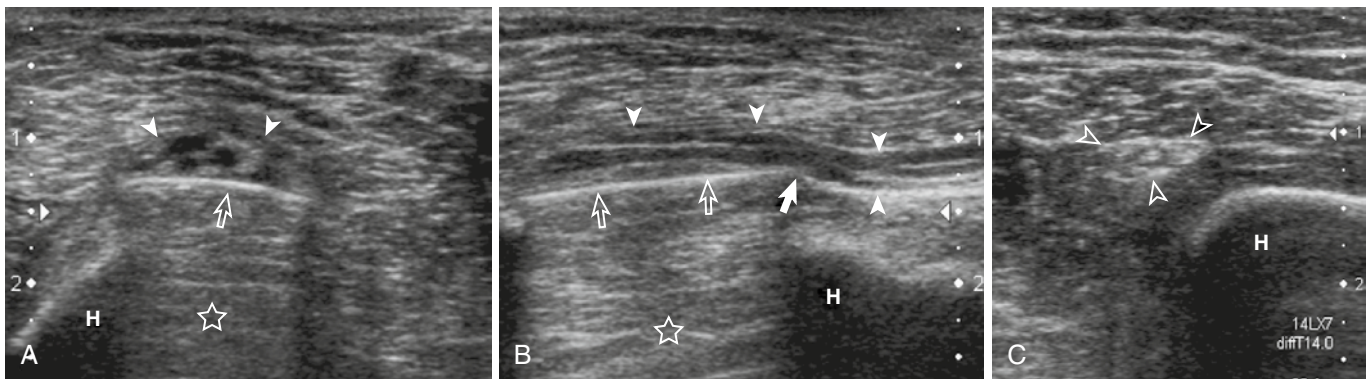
RADIAL NERVE TRACTION TRAUMA. A traumatic humeral shaft fracture was treated with internal fixation and was associated with radial nerve palsy. A and B, Short- and long-axis, 5- to 14-MHz ultrasound images show an enlarged radial nerve with enlarged fascicles (closed arrowheads) after nerve traction, overriding the orthopedic metal plate (open arrows) with its comet tail metallic artifact (open stars). There was no evidence of nerve interruption or pinched nerve at the junction between the metal plate and nerve (closed arrow). C, Short-axis ultrasound image shows the contralateral normal radial nerve (open arrowheads). H, humerus.
